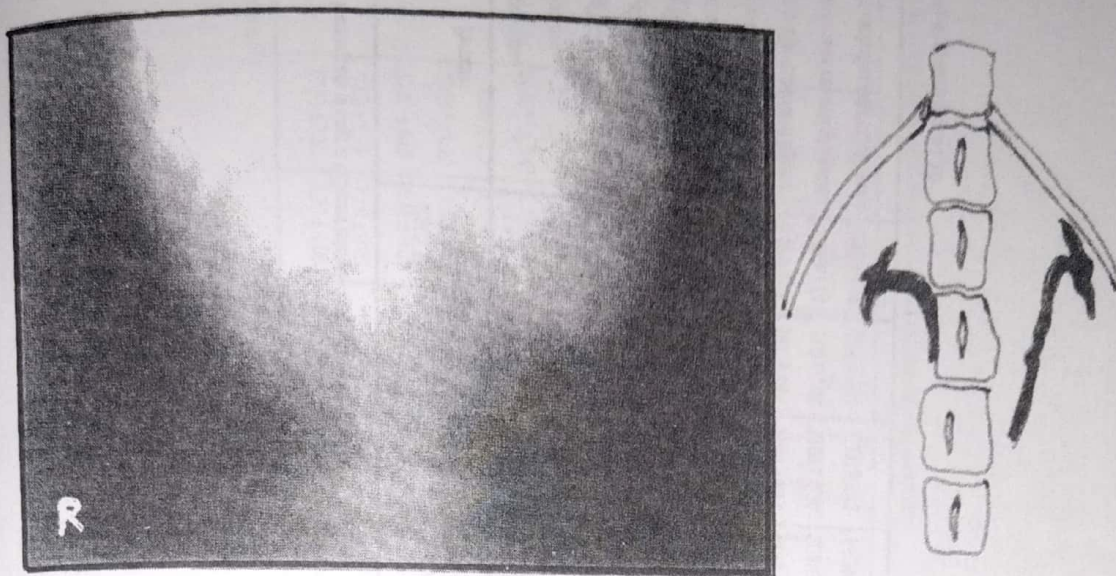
Vetrodorsal radiographical view after 6 weeks after removal of ligation. Both kidneys and ureters are appeared apparent normal and functioning.
